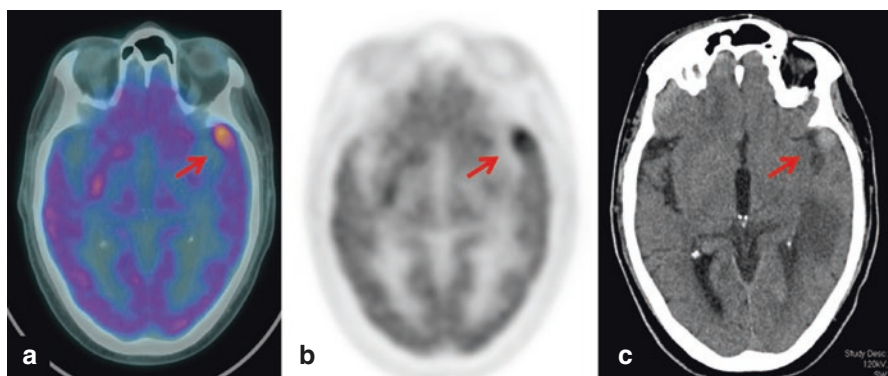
(a–c) Axial fused ^{18}F FDG PET/CT (a), axial ^{18}F FDG PET (b) and noncontrast CT (c) show a FDG-avid lesion in the left temporal lobe (a, b arrows) which corresponds to a hyperdense lesion on subsequent CT (c, arrow) in a patient who underwent PET/CT for lung cancer staging, in keeping with brain metastasis.
